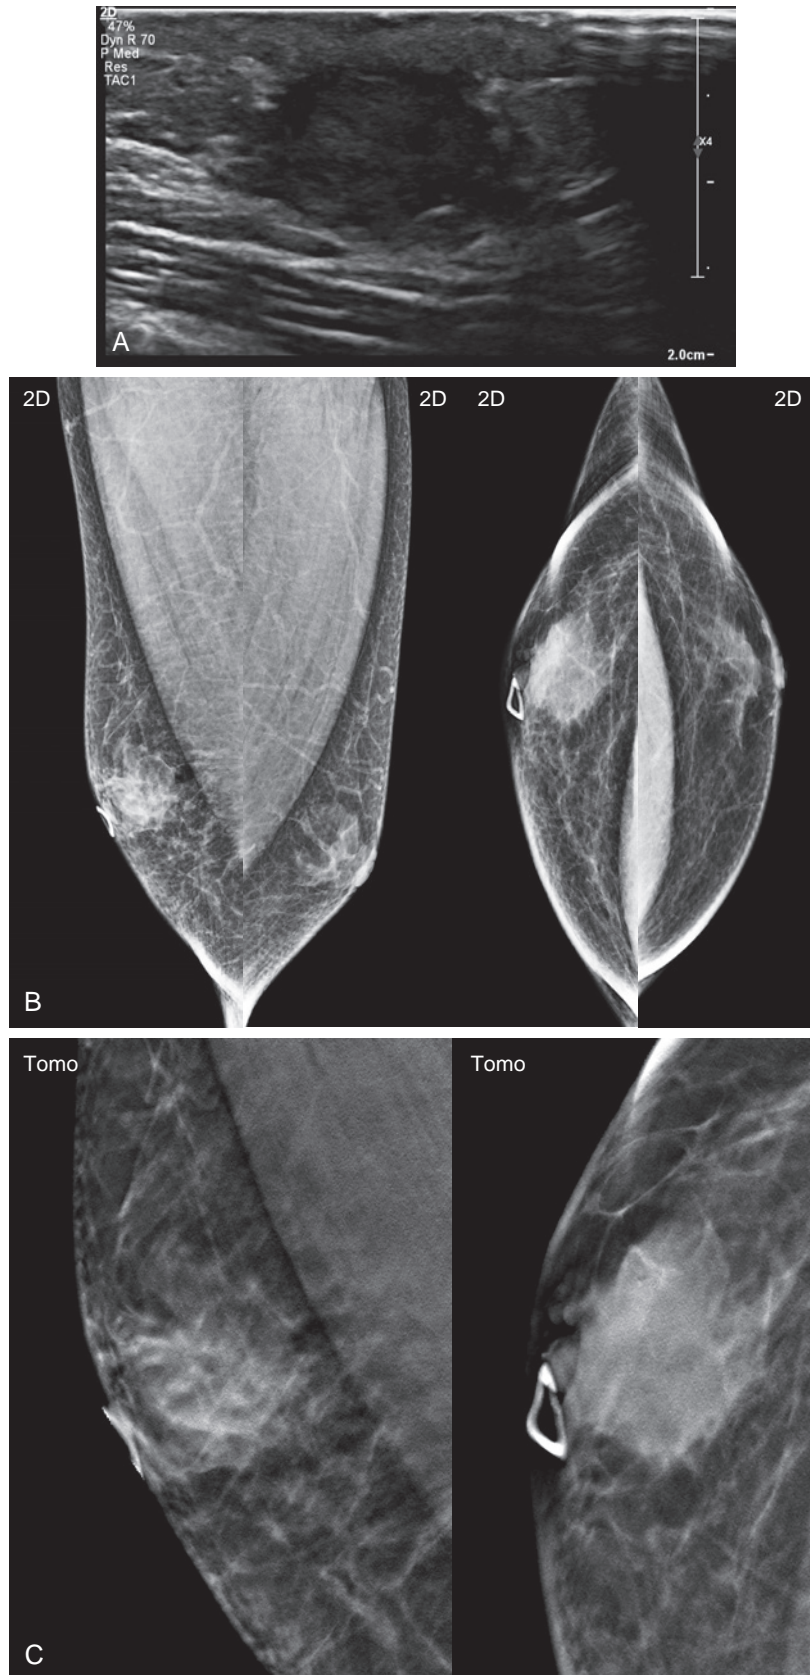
Abscess. A 58-year-old man presents with swelling under his right nipple 6 days after completing antibiotic treatment, with a persistent palpable region. (A) Ultrasound shows a 2.5-cm irregular hypoechoic mass. (B) 2D images show bilateral gynecomastia and an irregular mass in the right breast. (C) Tomosynthesis slice images show the mixed density but indistinct margins of the mass. Biopsy was performed, revealing acute and chronic inflammation.
